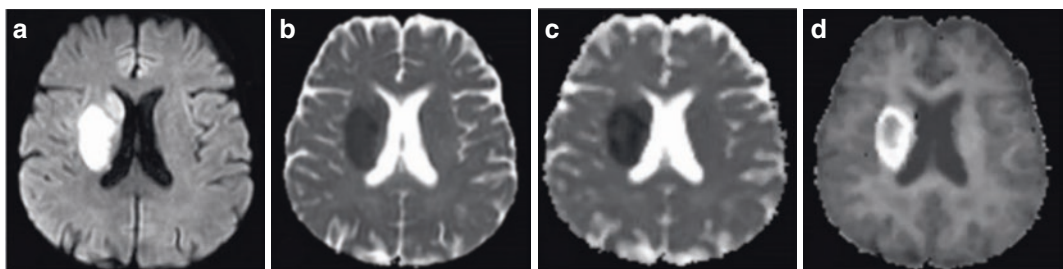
Acute right periventricular cerebral infarction. A 55-year-old male patient who presented with left-sided sensory disturbances for 8 h. Transverse DWI shows homogeneous hyperintense signals in the right periventricular area (a). Transverse ADC mapping (b) and MD
